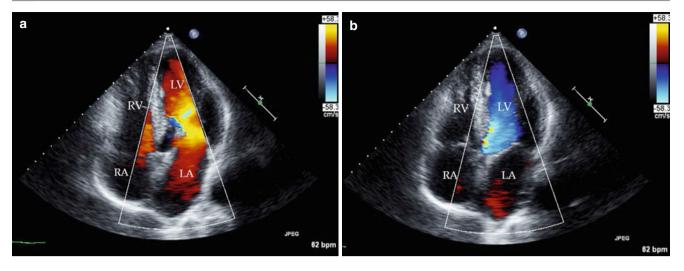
Apical four-chamber images with color-flow Doppler during diastole (a) and systole (b). *Red flow* indicates movement toward the transducer (diastolic filling); *blue flow* indicates movement away from
